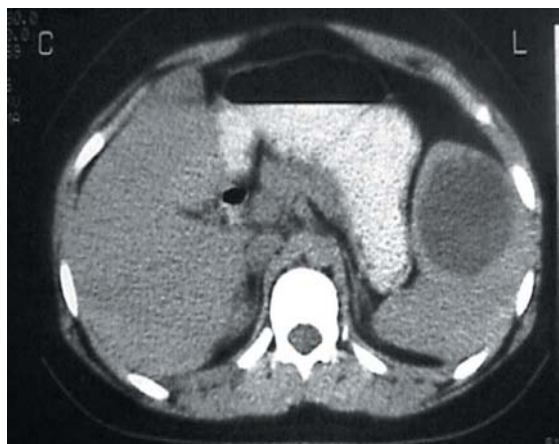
CT scan of Case 5 revealing cystic lymphangioma (3 x 4 cm) located at the upper pole of the spleen.
